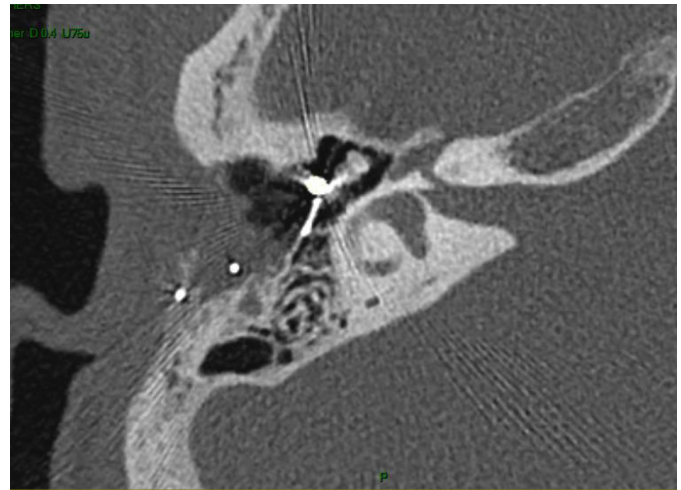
Axial image of the temporal computed tomography scan showing the floating mass transducer fixed to the short process of the incus of the right ear without displacement or massive fibrosis
